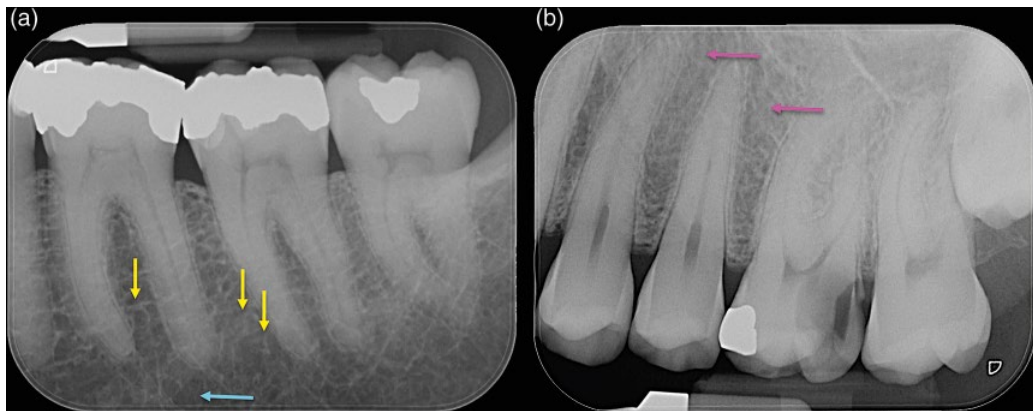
Periodontal ligament space. (a) Periapical radiograph of the mandibular right first, second and third molars. The predominantly horizontally oriented bony trabeculae (yellow arrows). Wider marrow spaces (blue arrow) may be mistaken for periapical radiolucencies. (b) The trabeculae in the maxilla (pink arrows) are thinner and more compact compared to those in the mandible.
